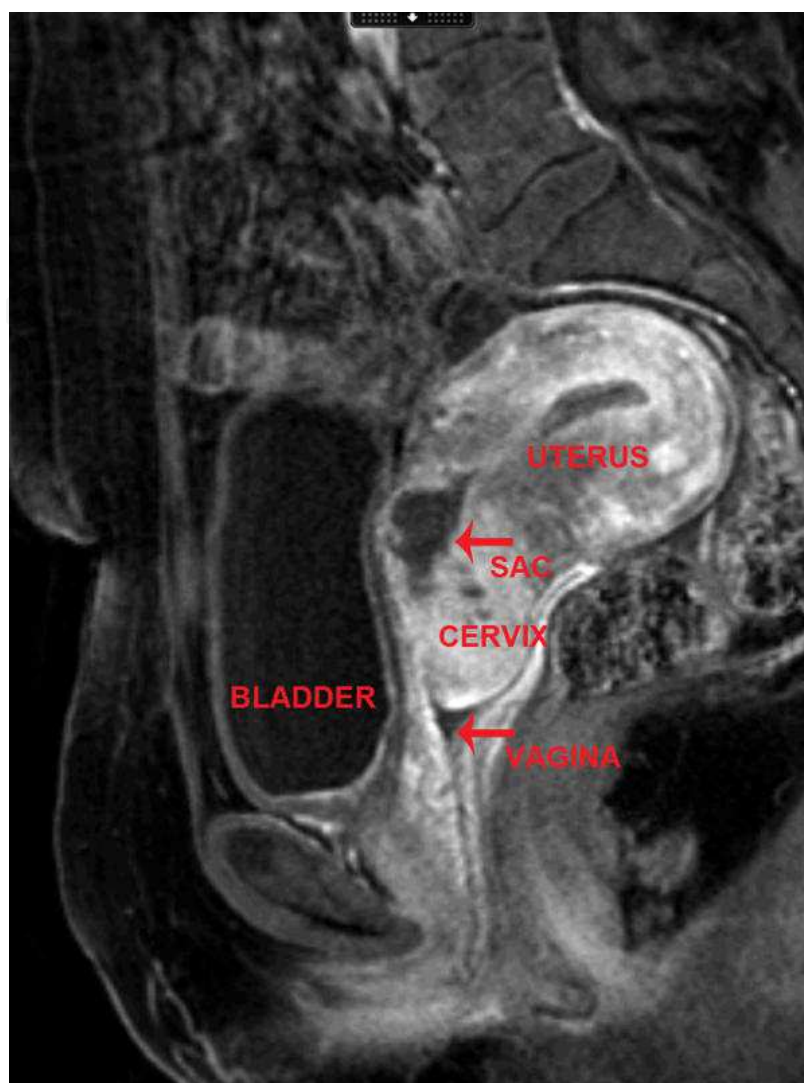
MRI of Cervical pregnancy
